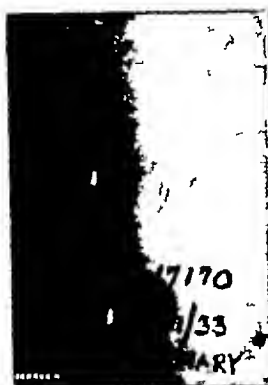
Preliminary roentgen examination of the gall-bladder area, before the oral administration of dye for cholecystography. The findings were negative.
